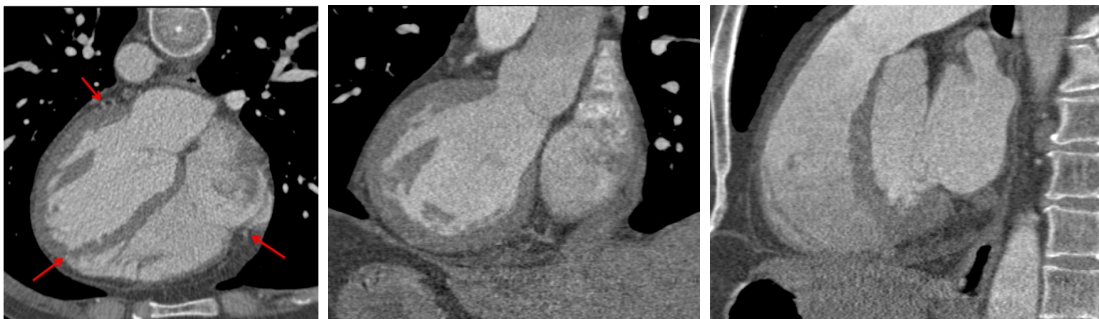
Cardiac CTA images (transversal, coronal and sagittal views). Red arrows point to the coronary arteries.
